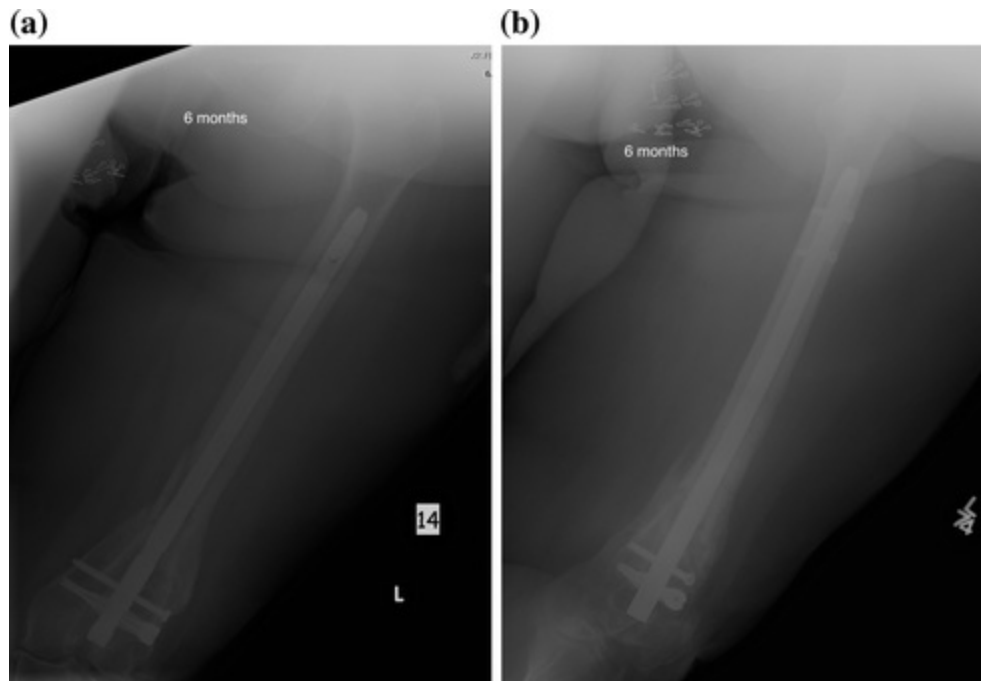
a Anteroposterior and b lateral left femur radiographs at 6 months showing consolidation across the nonunion site
